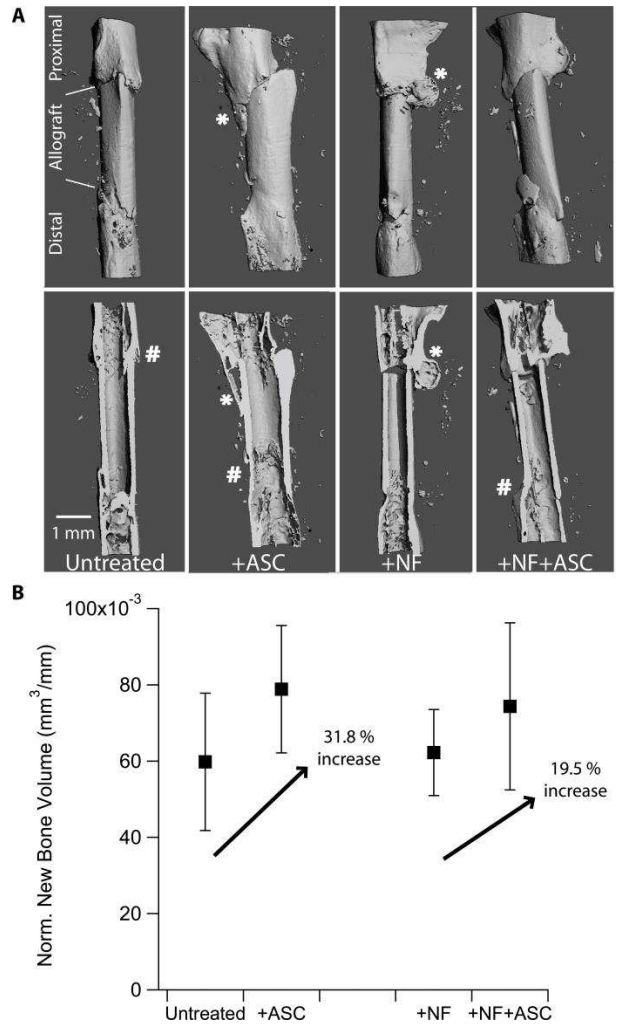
(A) Representative μ CT 3D reconstructions. (Top row) 3D reconstructions of the region of interest showing the femur defect, proximal, and distal host tissue and bone callus (*) (Bottom row) Longitudinal cross sections reveal graft incorporation at certain host-graft junctions (#). (B) μ CT data analysis (average \pm SE) shows Luc-ASCs treated allografts generally increased new bone volume formation. ASC treated allografts increased new bone volume by 31.8% compared to untreated allografts while nanofiber+ASC allografts only increased new bone volume by 19.5% compared to nanofiber allografts. However, these increases were not statistically significant.
